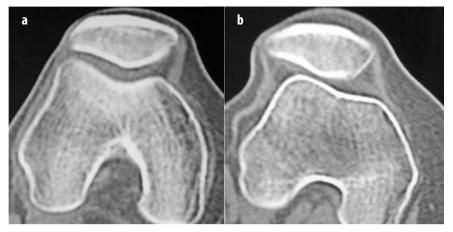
CT scan of patellofemoral joint without (a) and with (b) quadriceps contraction is very important to evaluate the degree of patellar instability
